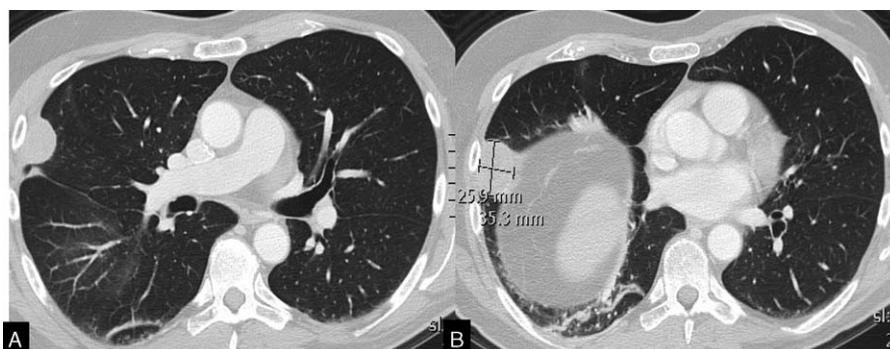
Patient 2. CT scan confirms the presence of 2 pleural lesions, the biggest one measures 2.6 × 3.5 cm and it is in the right middle lobe.
